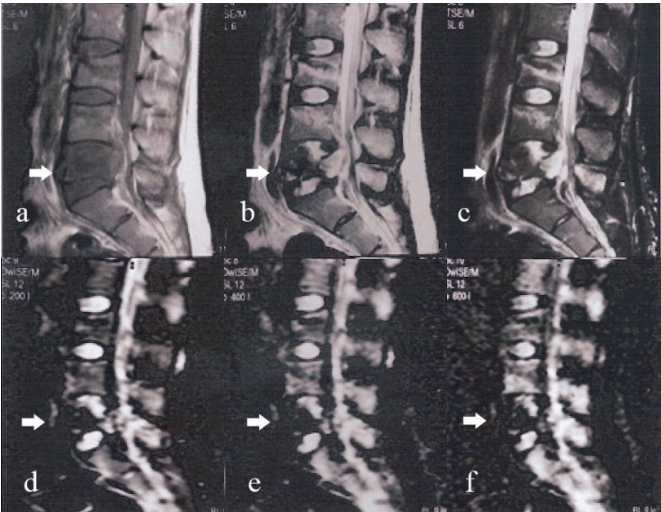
19-year-old woman who had traumatic L3, L4 and L5 (arrow) vertebral fractures with bone marrow edema on sagittal T1-weighted sequence (a), on sagittal T2-weighted sequence (b), on sagittal T2-weighted SPIR sequence (c), low signal intensities of fractures and high signal intensities of bone marrow edema on sagittal DWI at b value of 200 (d), 400 (e) and 600 s/mm² (f).
